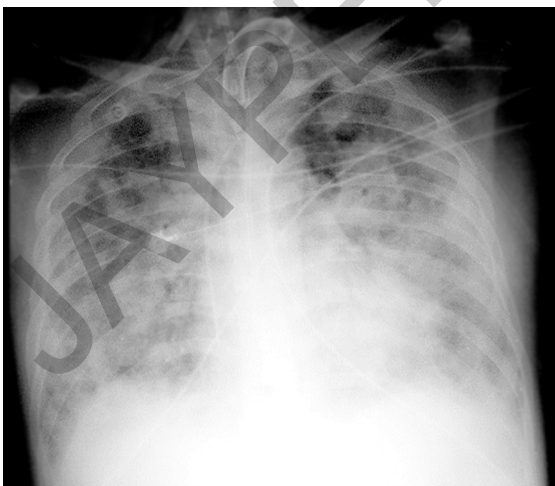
Chest X-ray—increased opacity, diffused alveolar infiltrates (honeycomb effect).
